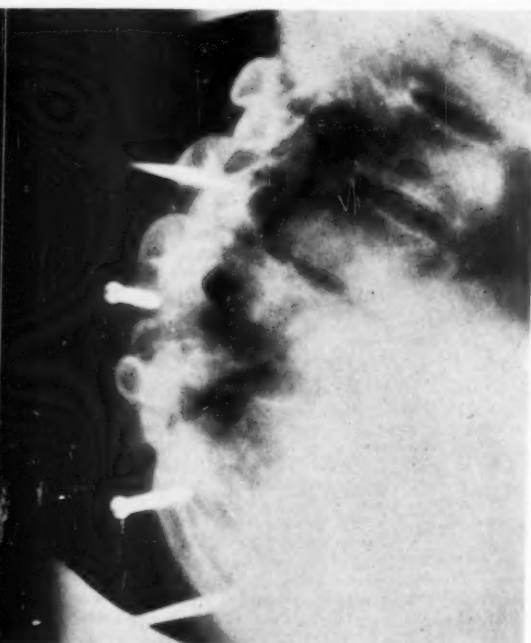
Case 7: Lateral view of graft. Firm union verified by radiography and biopsy.
